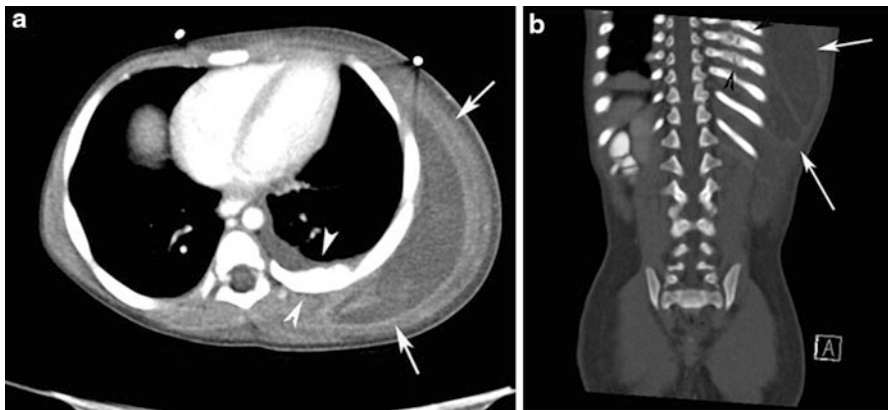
Axial (a) and coronal reconstructed CT image (b) in a 2-year-old male with multiple bruises from non accidental trauma showing lateral chest wall fluid collection (*arrows*) indicative of a hematoma or seroma from blunt direct trauma. Healing posterolateral rib fractures with associated small left pleural effusion are also noted (*arrowheads*)
